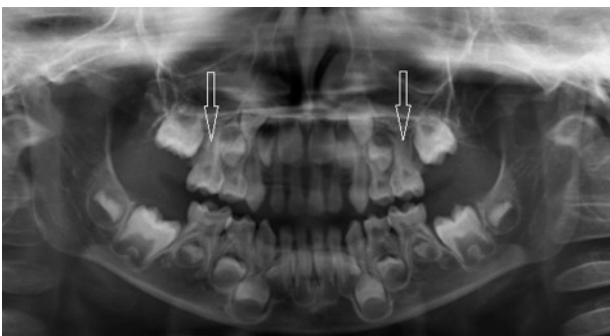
Agenesis. Panoramic radiograph of a 5.5-year-old patient, diagnosed with CNS neoplasm at the age of 2 years. Notice the absence of tooth buds (agenesis) of upper second premolars (arrows).
